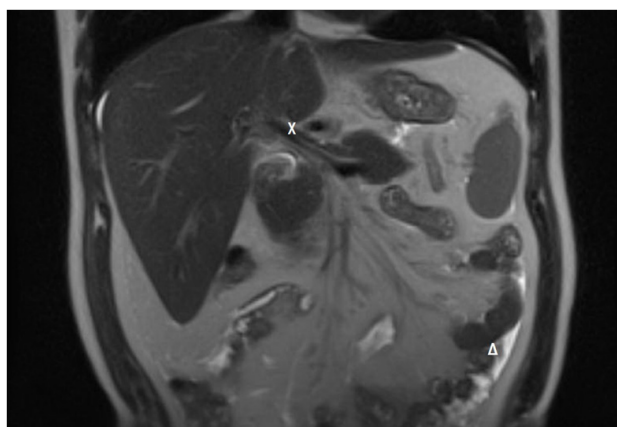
Abdominal MRI (Coronal T2 view): X Portal vein thrombosis, Δ Sigmoid inflammatory changes.
